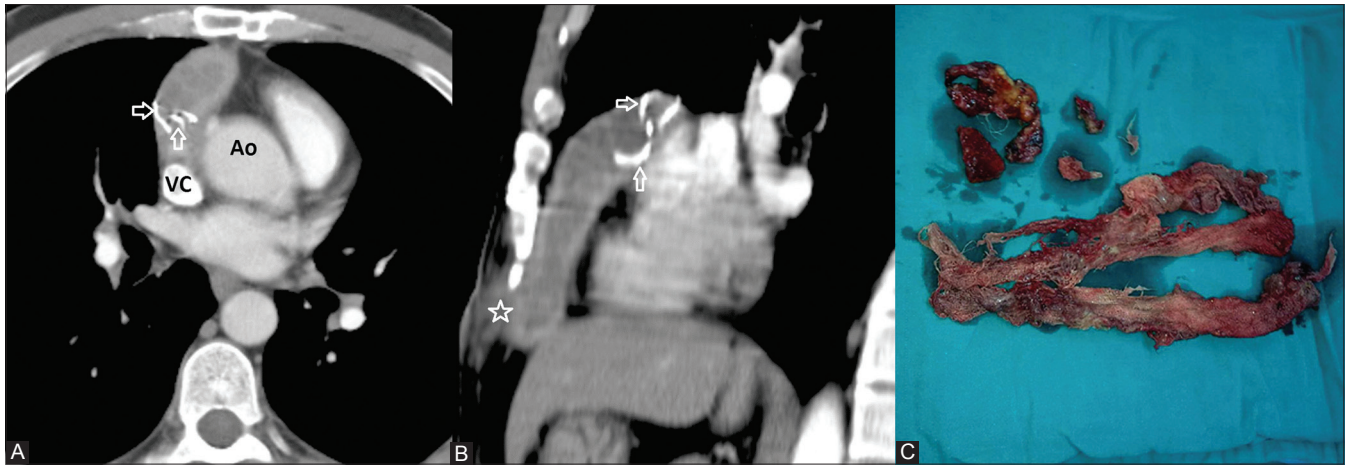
(A-C): Pericardial gossypiboma in a 36-year-old male patient who had undergone aortic valve replacement operation 18 months earlier. (A, B) An enhanced chest CT examination demonstrates well-defined right-sided intrapericardial mass lesion near the aortic valve which contains infolded linear dense sponge markers (arrows) and opens to the subxiphoid region with a fistula tract (asterisks). (C) The patient underwent a second operation, and a surgical gauze sponge was removed. VC, vena cava superior; Ao, aorta
